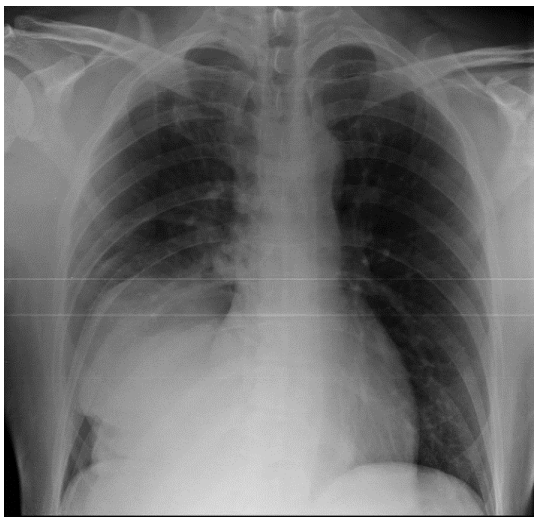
AP chest X-ray showing a radiopaque lesion in the right hemithorax.
